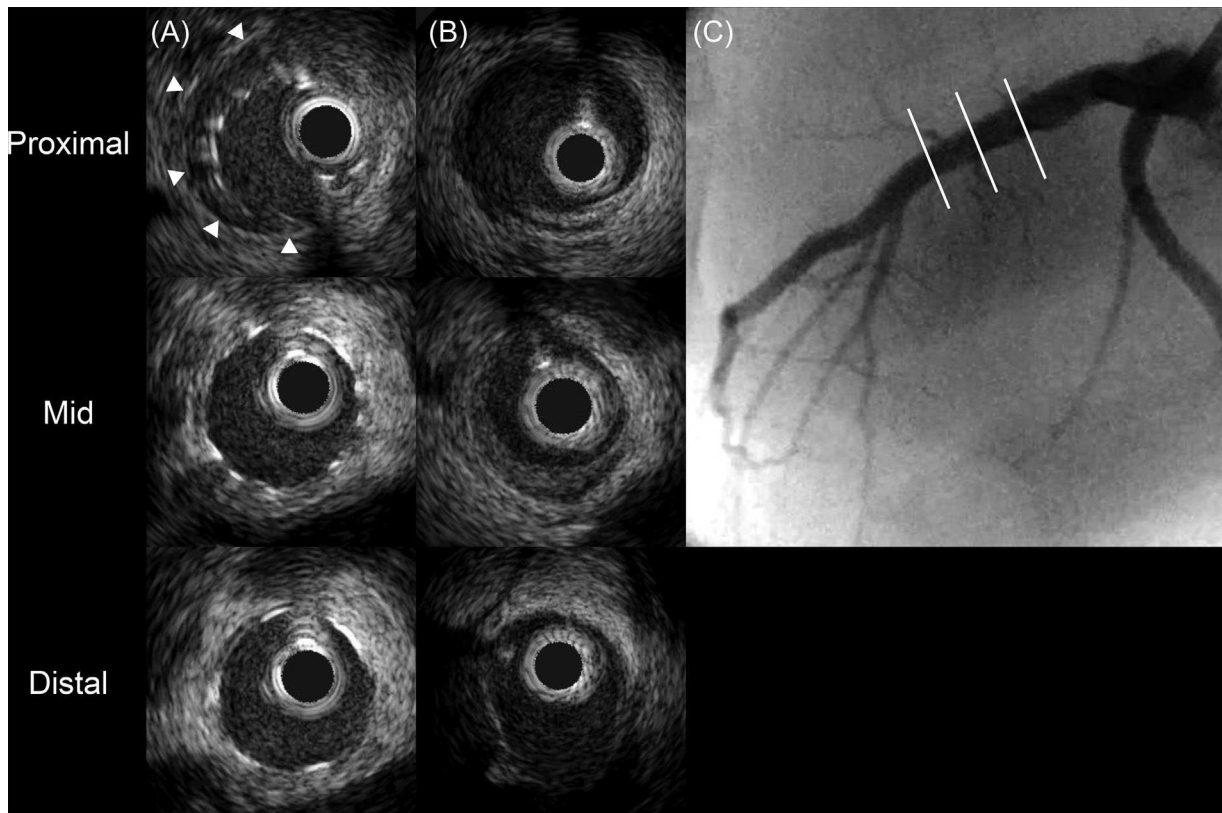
Representative IVUS findings after stent retrieval on the 14th day. Inappropriate expansion of stents at the proximal site was confirmed by intravascular ultrasound (IVUS) (A, white arrow heads). IVUS findings showed that proliferation of tissue resembling neointima was observed, but lumen area was preserved (B). Final angiography revealed an absence of vessel rupture or occlusion (C)
